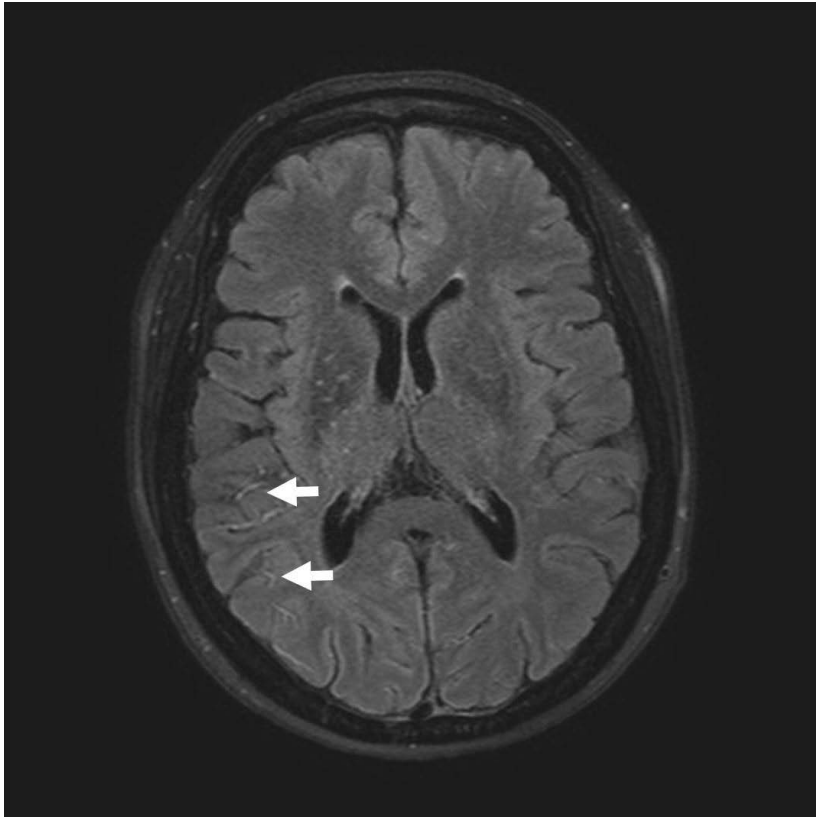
Ivy-sign (arrows) in a brain MRI-image.
